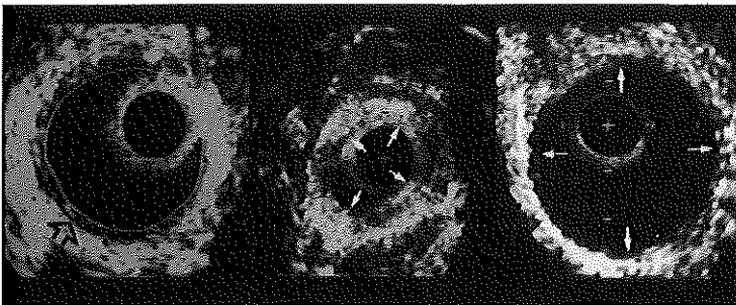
Intravascular ultrasound cross-sections of venous bypasses showing differences in lumen areas. Left panel shows the contour of the free lumen area (FLA) and the vein wall thickness (open arrow). Middle panel: example of a small lumen (FLA = 5.6 mm^2). Right panel: example of a large patent lumen (FLA = 12.1 mm^2). + = Catheter; calibration = 1 mm .
